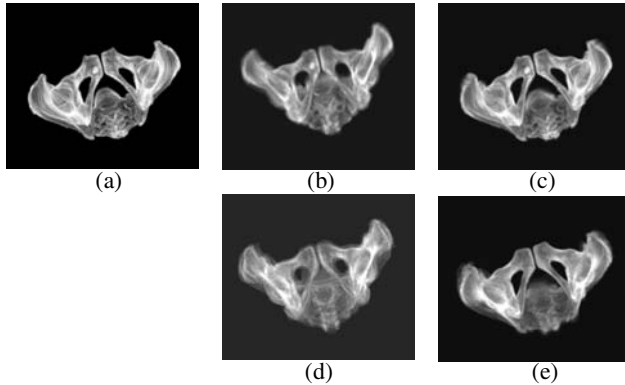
Visual comparison of affine registration method and our registration method in averaging the aligned pelvis CT images. 3D rendering images are displayed. (a) Model pelvis, (b) the average of 10 synthesized pelvises aligned by affine registration method, (c) the average of 10 synthesized pelvises aligned by our registration method, (d) the average of 5 real pelvises aligned by affine registration method, (e) the average of 5 real pelvises aligned by our registration method.
